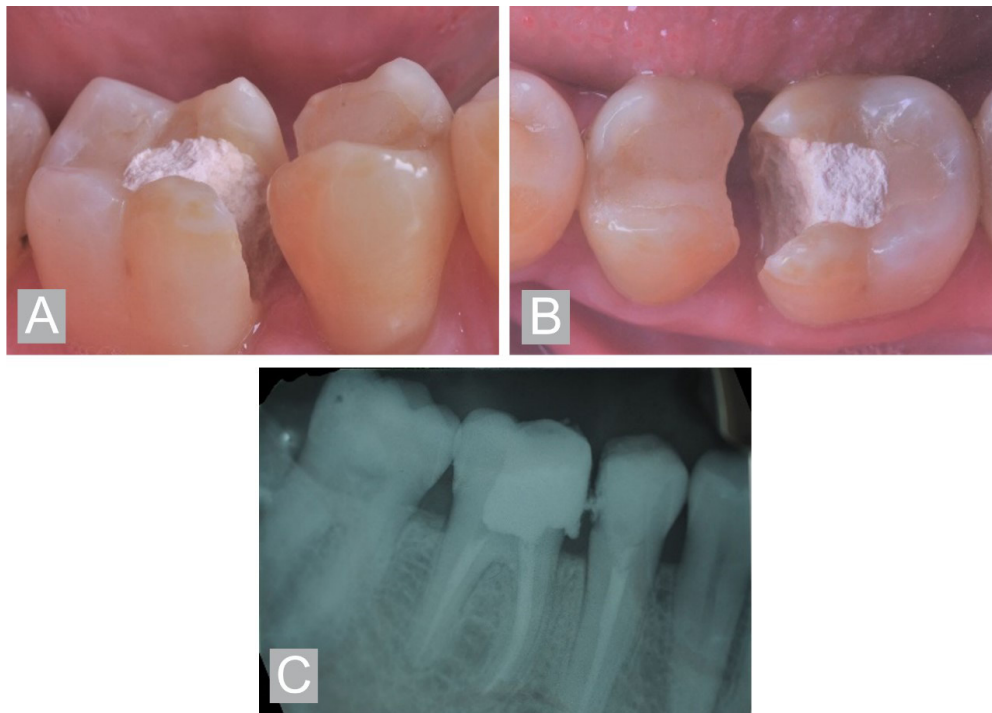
(A) Initial photographs and radiography of the clinical situation; (B) Occlusal and lateral view of teeth #46 and #45. It is possible to observe that both have deep gingival margins with extensive Class II cavities; (C) Initial radiography showing the deep gingival margins.
